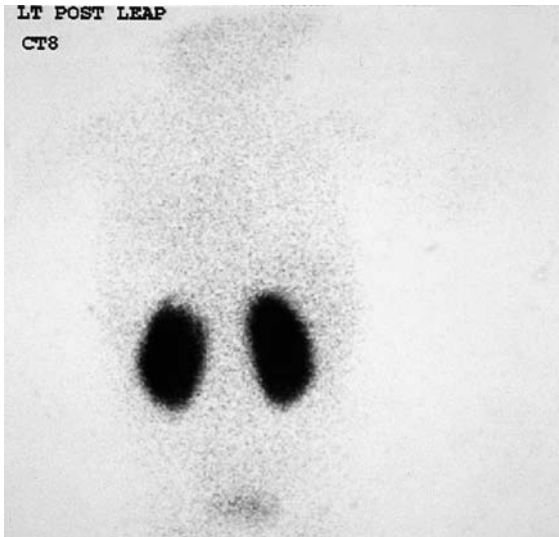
DMSA scintigraphy in a case of 'cryptic' duplication. The subtle defect at the left upper pole represents a non-functioning, non-dilated moiety.
